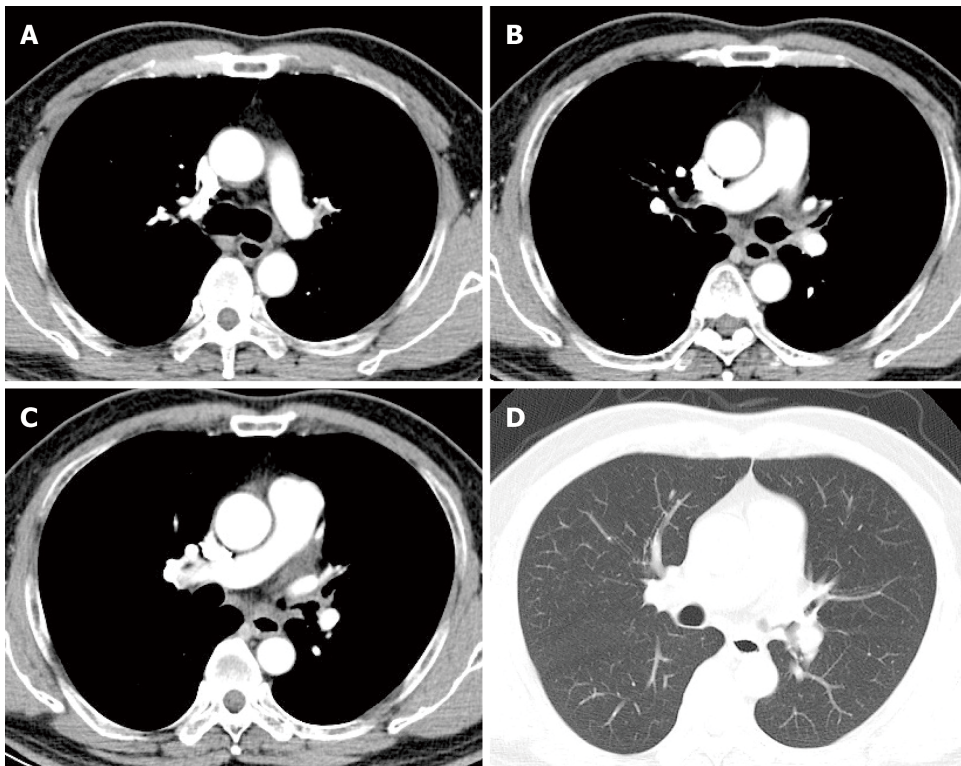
Repeated chest computed tomography scan images (2019-03-24). A-C: Mediastinal window; D: Lung window. Repeated chest computed tomography scan revealed improvement and diminishment of the mass-like lesion and mediastinum and hilum lymph nodes compared to the computed tomography scan done on 2018-4-7.
